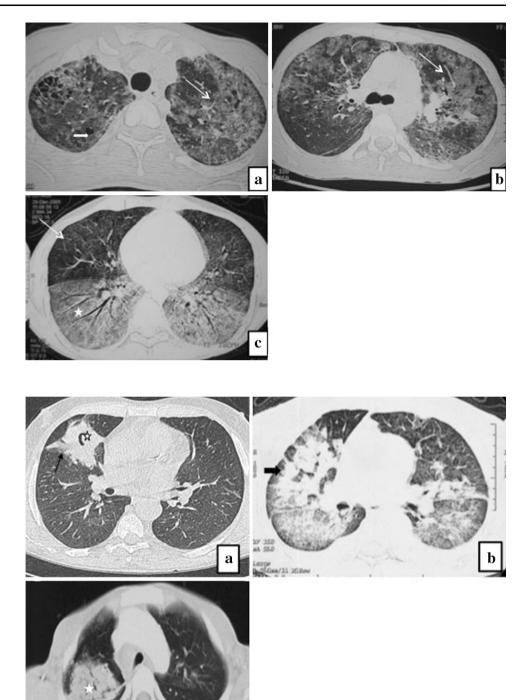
a Semi-invasive aspergillosis in an immumocompromised patient, chest CT shows cavity with eccentric soft tissue (asterisk) and surrounding GGOs (black arrow). GGOs represent hemorrhage secondary to vascular invasion. b Airway Invasive Aspergillosis, chest CT shows coalescing areas of consolidation with GGOs in right lung (black block arrow in b). c Disseminated Histoplasmosis in a post-renal transplant patient. Chest CT shows areas of consolidation in right upper lobe (asterisk)
